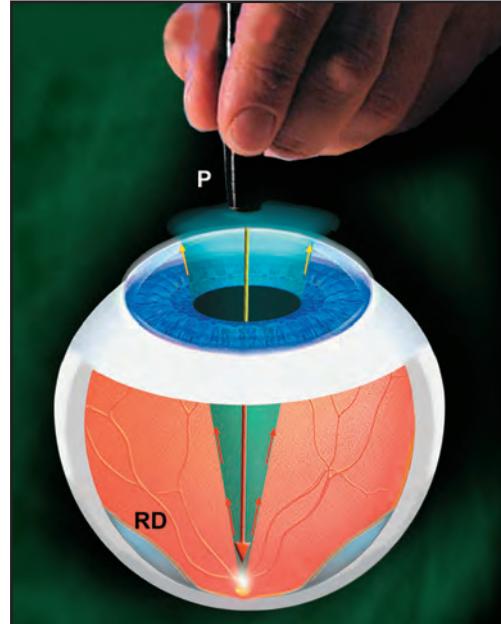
B-Scan Ultrasound used in Dislocated Intraocular Lens. If a vitreous hemorrhage or severe corneal edema is present, a B-scan ultrasound (P) should be used to determine the position of the IOL, and to rule out the possibility of a retinal detachment (RD). (Art from Jaypee - Highlights Medical Publishers).
